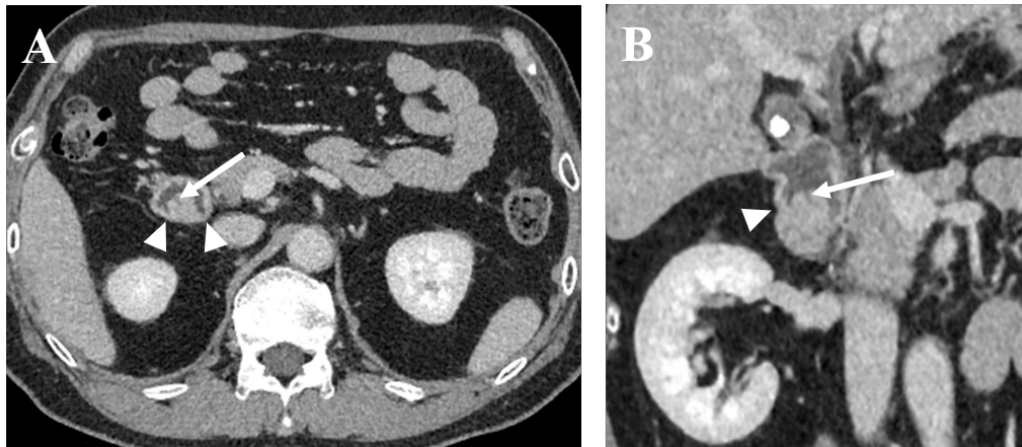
Heterotopic pancreas in the duodenum in a 60-year-old woman. Axial (A) and coronal (B) portal venous phase CT images showed a 1.3 cm, ill-defined, bell-shaped (arrowheads), endoluminal intramural mass with homogeneous enhancement in the duodenum (similar to the enhancement of the orthotopic pancreas). A small ductlike structure (white arrows) was observed within the lesion, extending to the surface.
